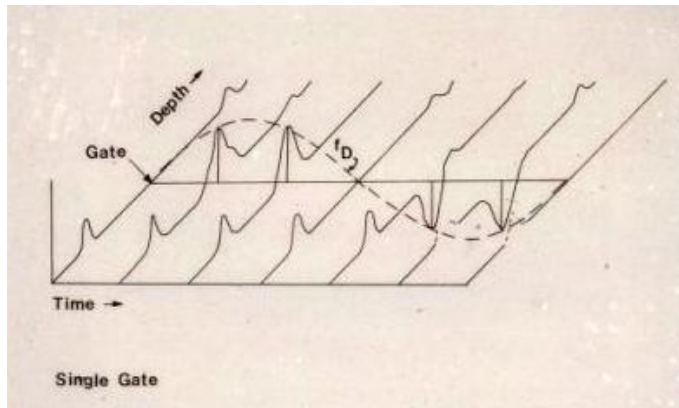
Operation of pulsed Doppler in the time domain.
